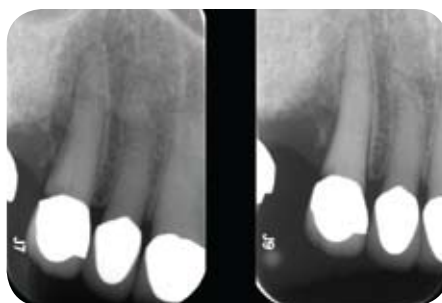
The periapical radiographs show with more detail the involved areas around tooth No. 6.
